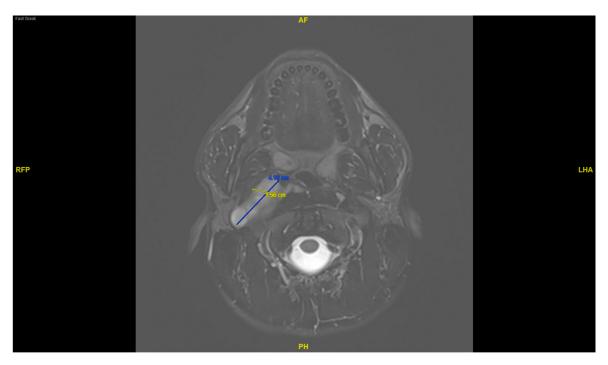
Axial T2-weighted MRI showing hyperintensity
